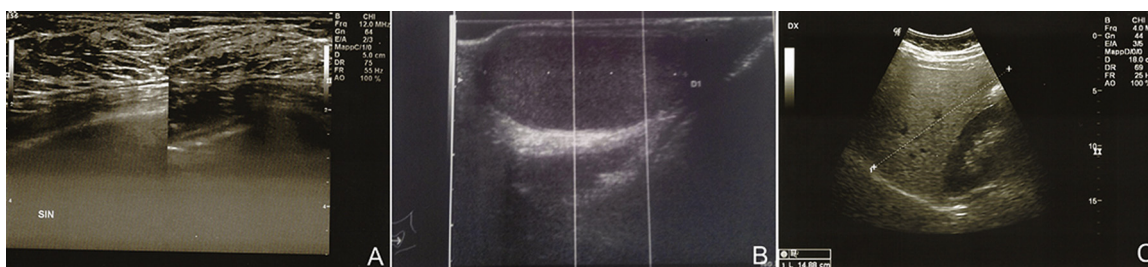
(A) The breast ultrasound scan showed monolateral gynecomastia. Moreover there are no solid nodular or cystic formations. (B) The testicular ultrasound scan showed normal-sized organ. (C) The abdominal ultrasound scan showed normal-sized adrenal glands, excluding an estrogen-producing adrenal tumor and normal-sized hepatic organ.
